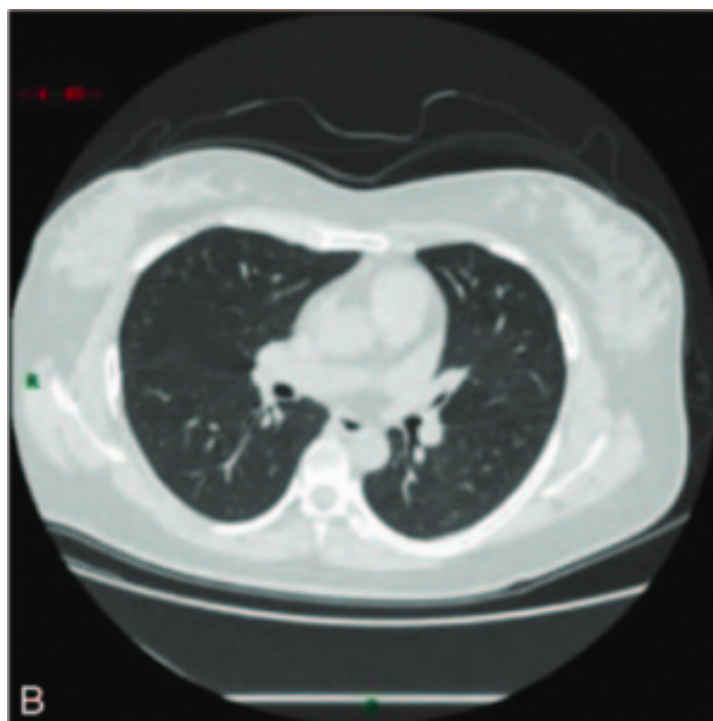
Mar 24, 2020, CT: most of the lung lesions are absorbed.¹
